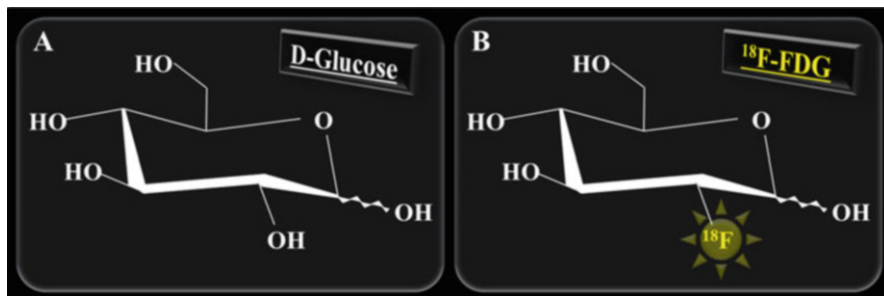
Chemical structural formula of D-glucose and ^{18}F -FDG.
